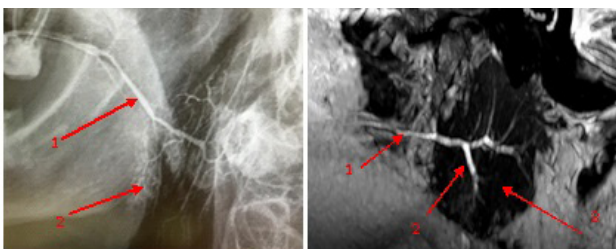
A 26-year-old patient. Parotid salivary glands. Normal condition. (1a). Radiographic sialogram (1b). MR sialogram of PSG on the right.
